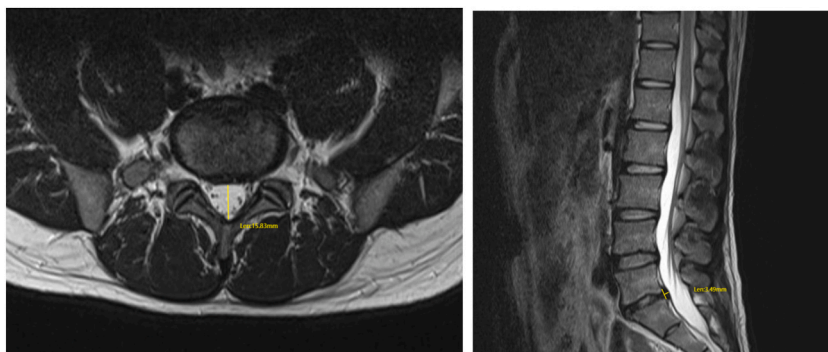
Sagittal (right) and axial (left) T2-weighted MRI of the lumbar spine after one year of conservative treatment. The diameter of the spinal canal on the cross-section was 15.83 mm, and the sagittal protrusion length of the L5/S1 intervertebral disc was as high as 3.49 mm.
